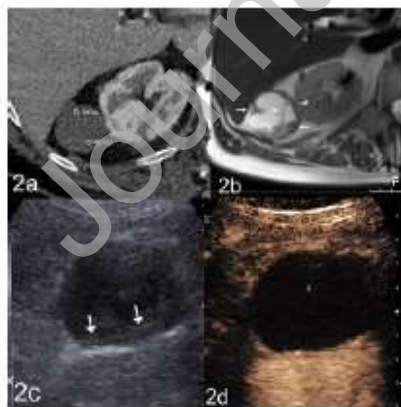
An 81-year-old male patient with von Willebrand disease. An axial-enhanced CT image (a) shows a heterodense lesion of the right kidney without enhancement with a prominent wall, classified as BII-F. An axial T2-weighted native MR image (b) shows the irregularly thickened wall, septation (arrowheads), and nodular internal thickening (arrows). Some diffusion restriction is seen, although no definite enhancement was evident after giving contrast medium (not shown); classified at MRI as BIII. A long axis US image (c) shows the cyst filled with hyperechogenic material (arrows) mimicking wall thickening, but the corresponding CEUS image (d) shows only an evident wall and no internal enhancement; classified as BII-F at CEUS.
